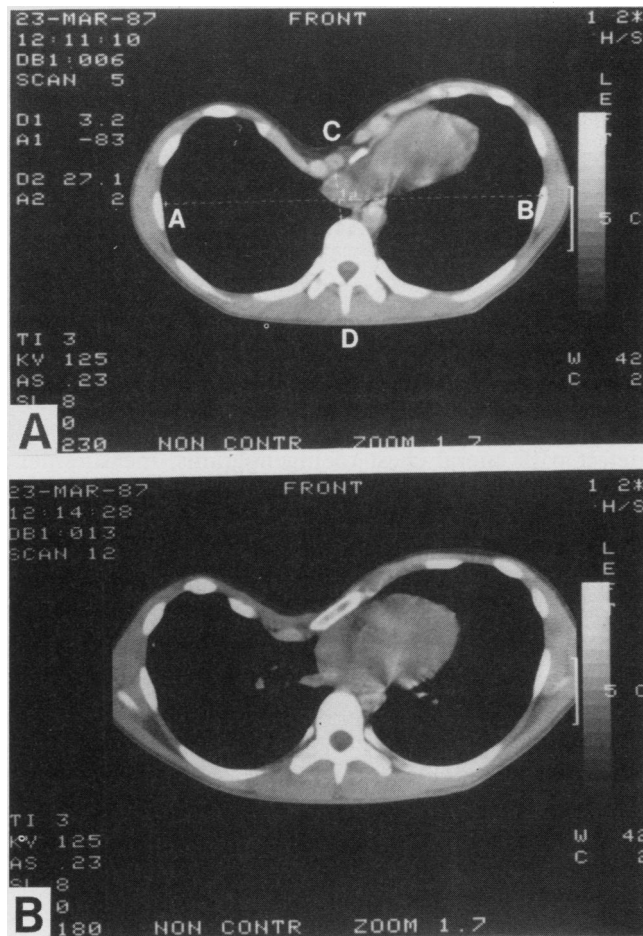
Chest CT scan of pectus excavatum. (A) CT image at xiphoid with A-B (transverse diameter) and C-D (anterior-posterior diameter) indicated for calculation of pectus index $A-B/C-D$. (B) CT image demonstrating angulation of sternum to the right in the severe defect.
